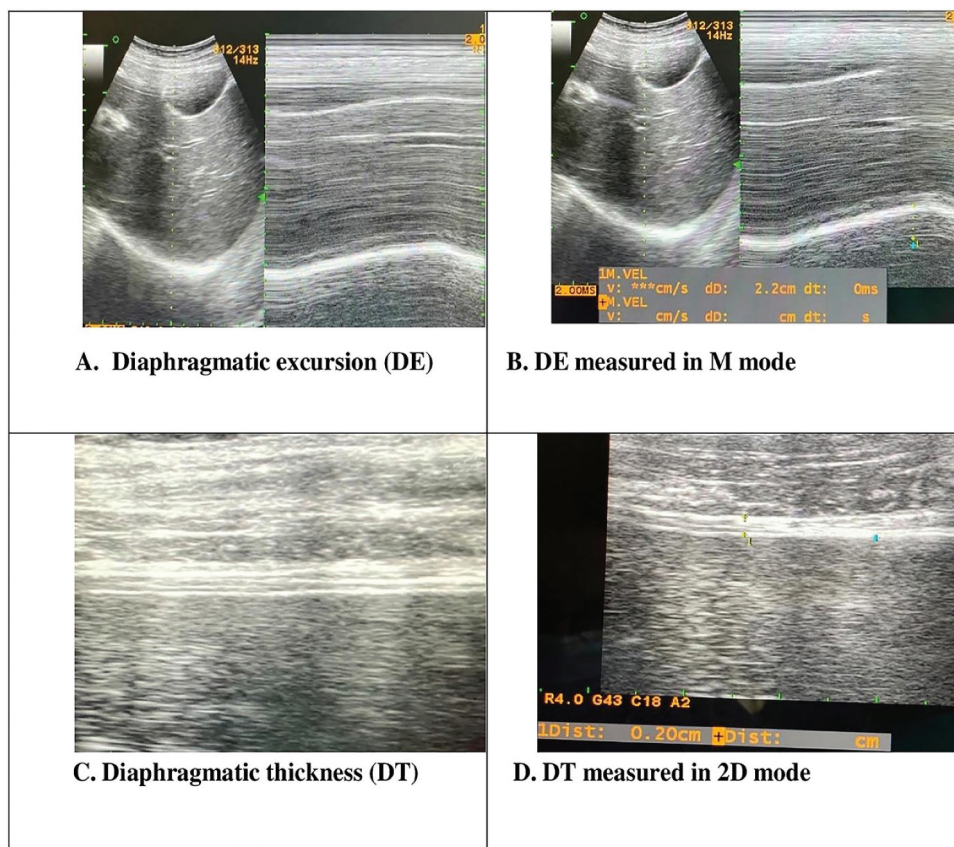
M-mode and 2D-mode ultrasonographic images of diaphragmatic function.
